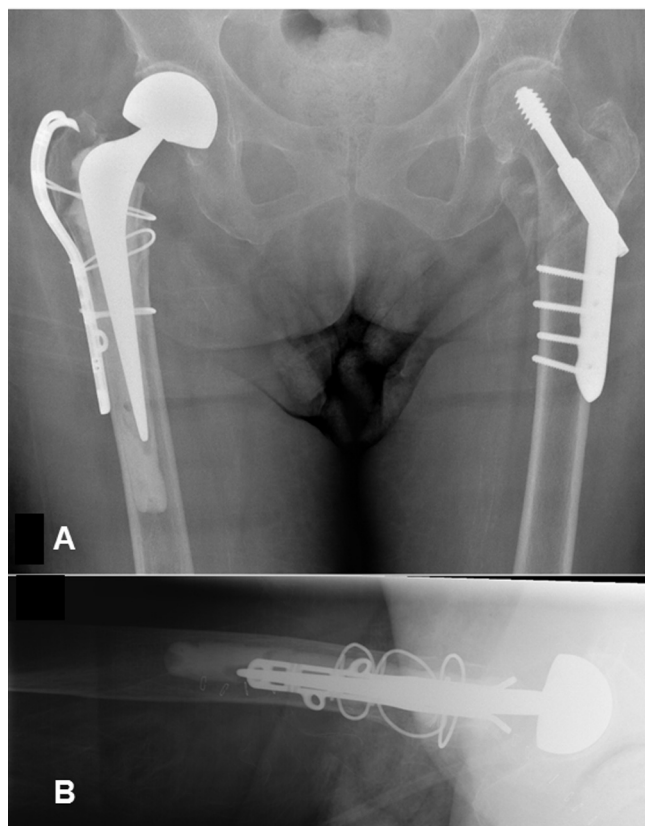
6 week post-operative X-rays of bipolar hemiarthroplasty and proximal femur plate fixation (A – Anteroposterior X-ray of pelvis, B – Lateral X-ray of right hip).
